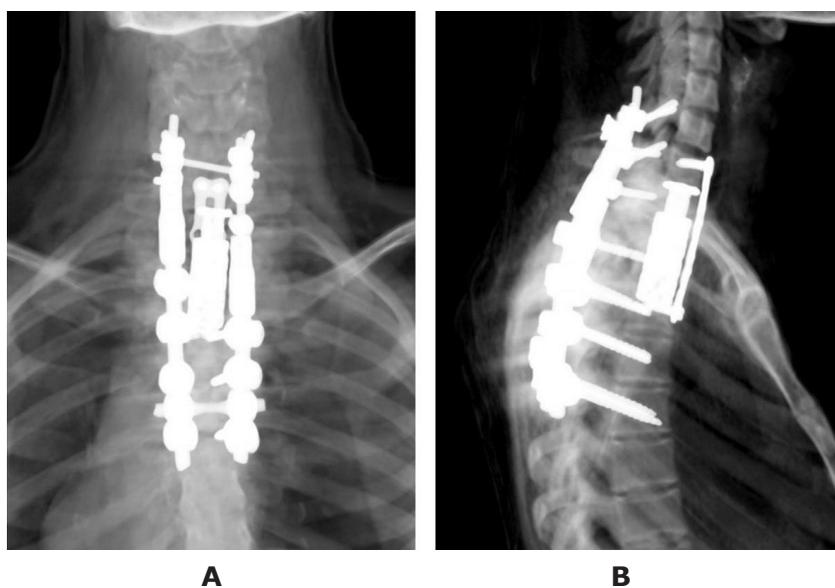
Radiography of the area of the cervical-thoracic junction after the second stage of surgery: A – anteroposterior projection; B – lateral projection
